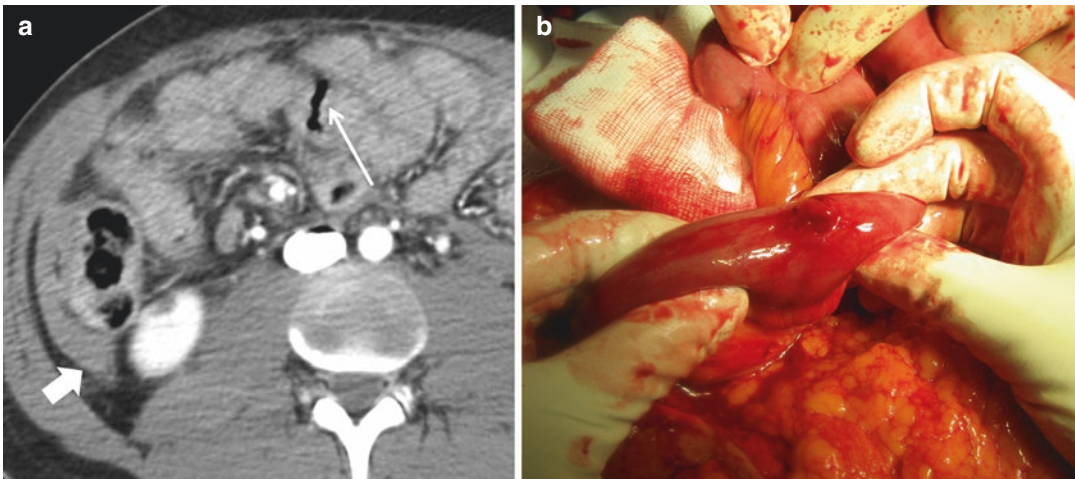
Discontinuous bowel wall. (a) Axial CT contrast-enhanced image shows a wall discontinuity (arrow) on the anterior, antimesenteric wall of a small bowel loop, with extraluminal air and hemoperitoneum
